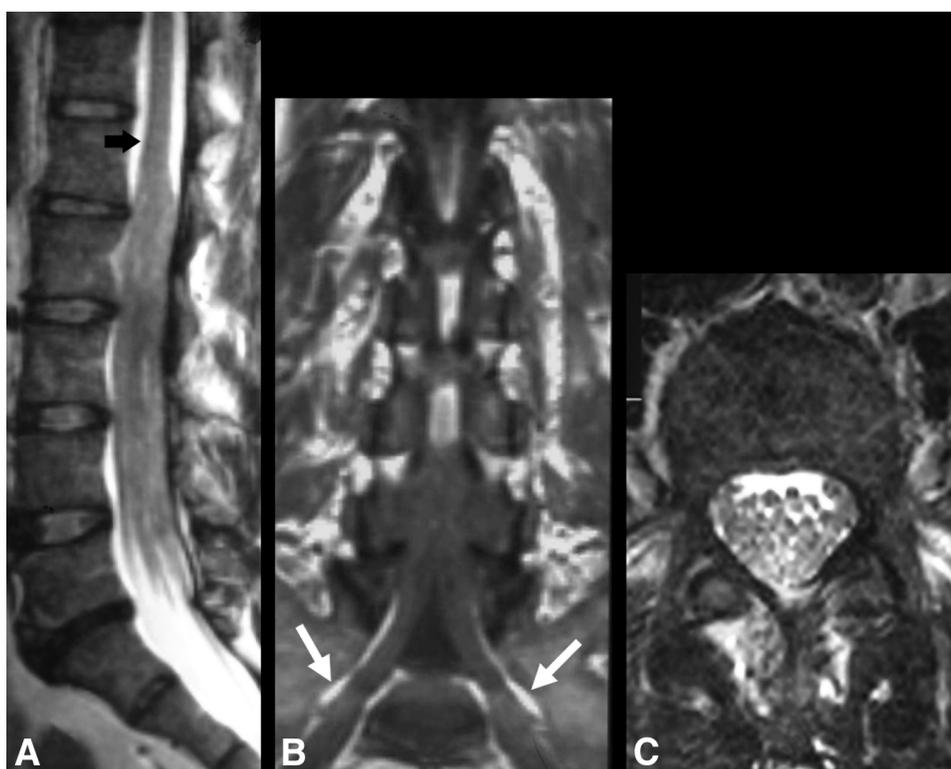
Patient with CMT1A carrying the duplication in homozygosity (Pareyson et al., 2003). Midline sagittal T2-weighted (A), coronal spin-echo T1-weighted (B), and axial T2-weighted (C) images showing dramatic hypertrophy of the spinal roots, almost completely filling the spinal canal, and of the S1 ganglia (white arrows in B). Compare the normal spinal cord size (black arrow in A) with the enlargement of the cauda equina roots.
